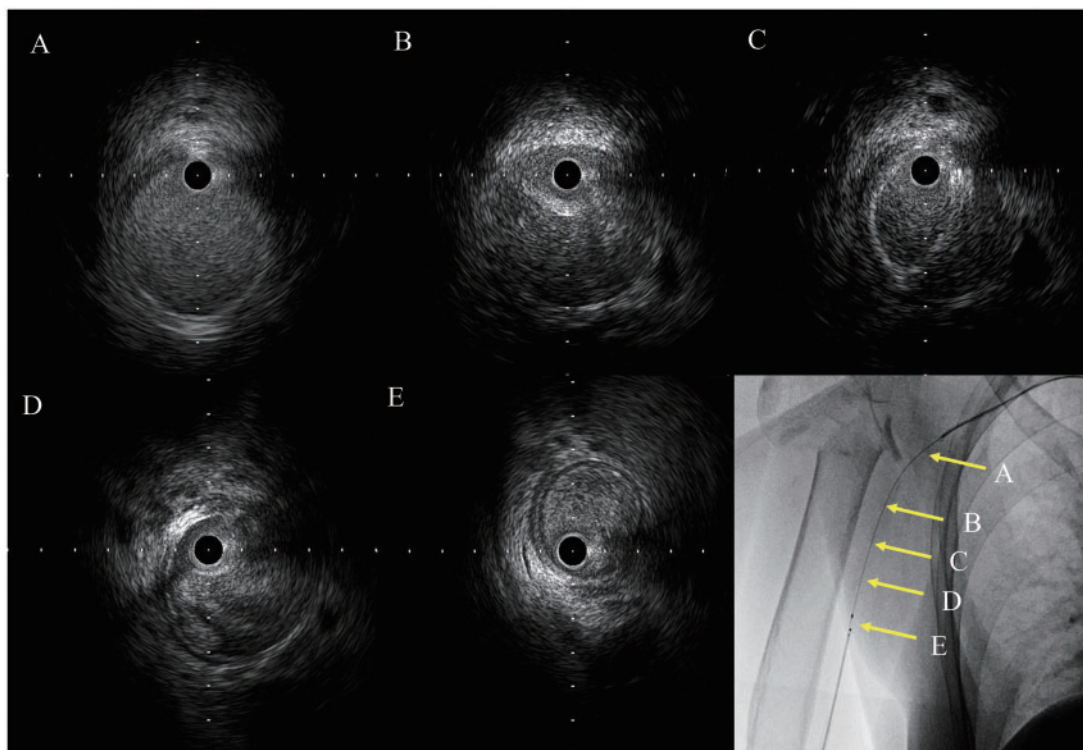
Evaluation of the right axillary artery using intravascular ultrasonography. Proximal normal site (A), injured site with dissection and thrombosis (B–D), and normal brachial artery (E).
